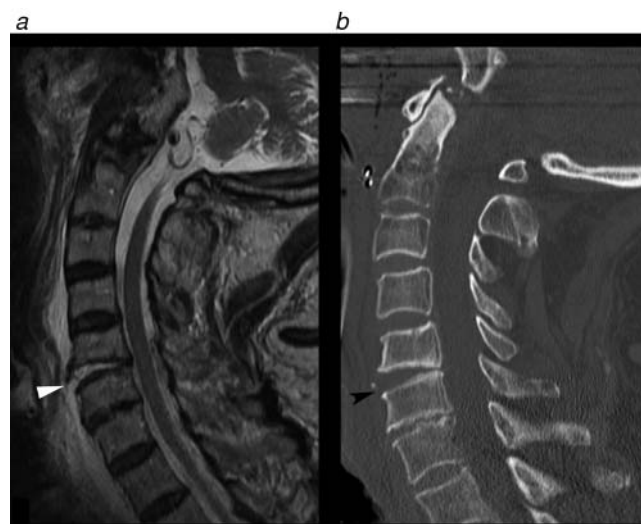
Magnetic resonance imaging may be performed in the setting of cervical spine trauma as a secondary test to evaluate for soft tissue injuries, such as ligamentous injury and disk injury (*a*, disruption of the anterior longitudinal ligament and C5–C6 disk injury with associated prevertebral fluid collection, *white arrowhead*). Signs of ligamentous injury on a computed tomographic scan may be relatively subtle by comparison (*b*, anterior widening of the C5–C6 intervertebral disk space, *black arrowhead*).
